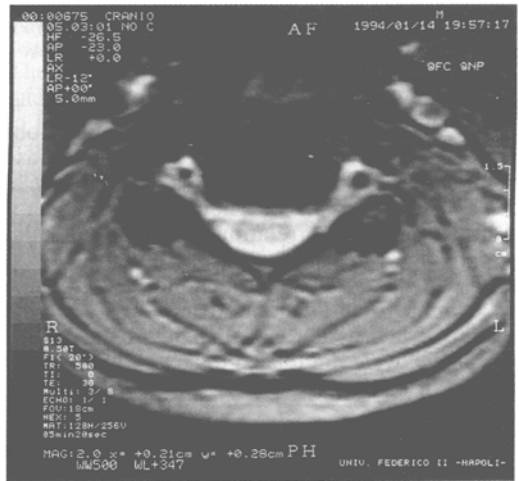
Axial T2-weighted gradient-echo sequence (0.5 T) at the level of the middle cervical cord in an FD patient (No. 11) showing the reduced antero-posterior diameter of the cord and the increased signal of the posterior columns.
